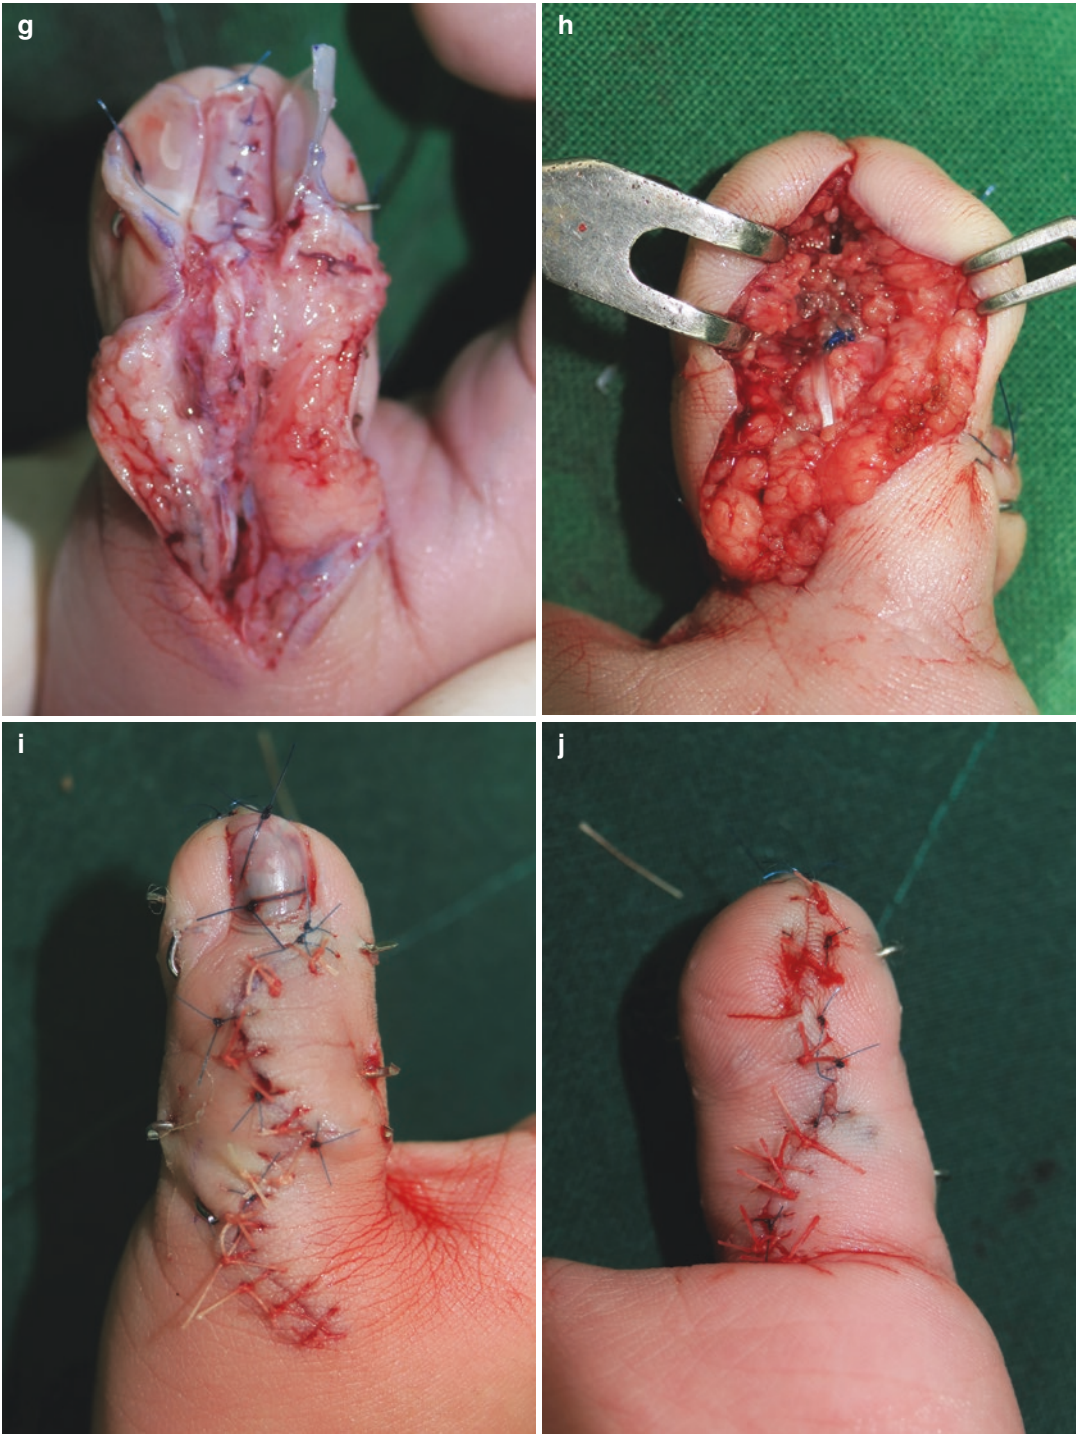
(a) Type III polydactyly with very symmetrical nail plate and similar size of distal phalangeal bone on the radiograph. (b–d) A zigzag incision matching volar and dorsal surfaces is made. Small Z-plasty is designed on the pulp tip. (e) The required width of bone is then excised from the proximal and distal phalanges, using a fine osteotome, to complete the longitudinal osteotomies. (f) Transverse bone fixation with multiple 0.7 mm Kirschner
